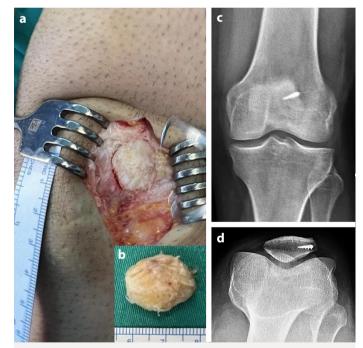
(a) Intraoperative appearance of the fragment before removal. (b) Bipartite patella fragment after excision. (c) Anteroposterior (d) tangential knee radiographs showing metallic anchors and total removal of the fragment without residue.
